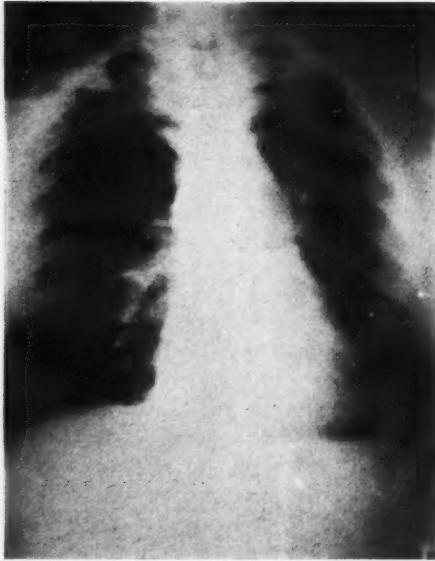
The tumor shows marked regression two weeks after the last x-ray treatment.
